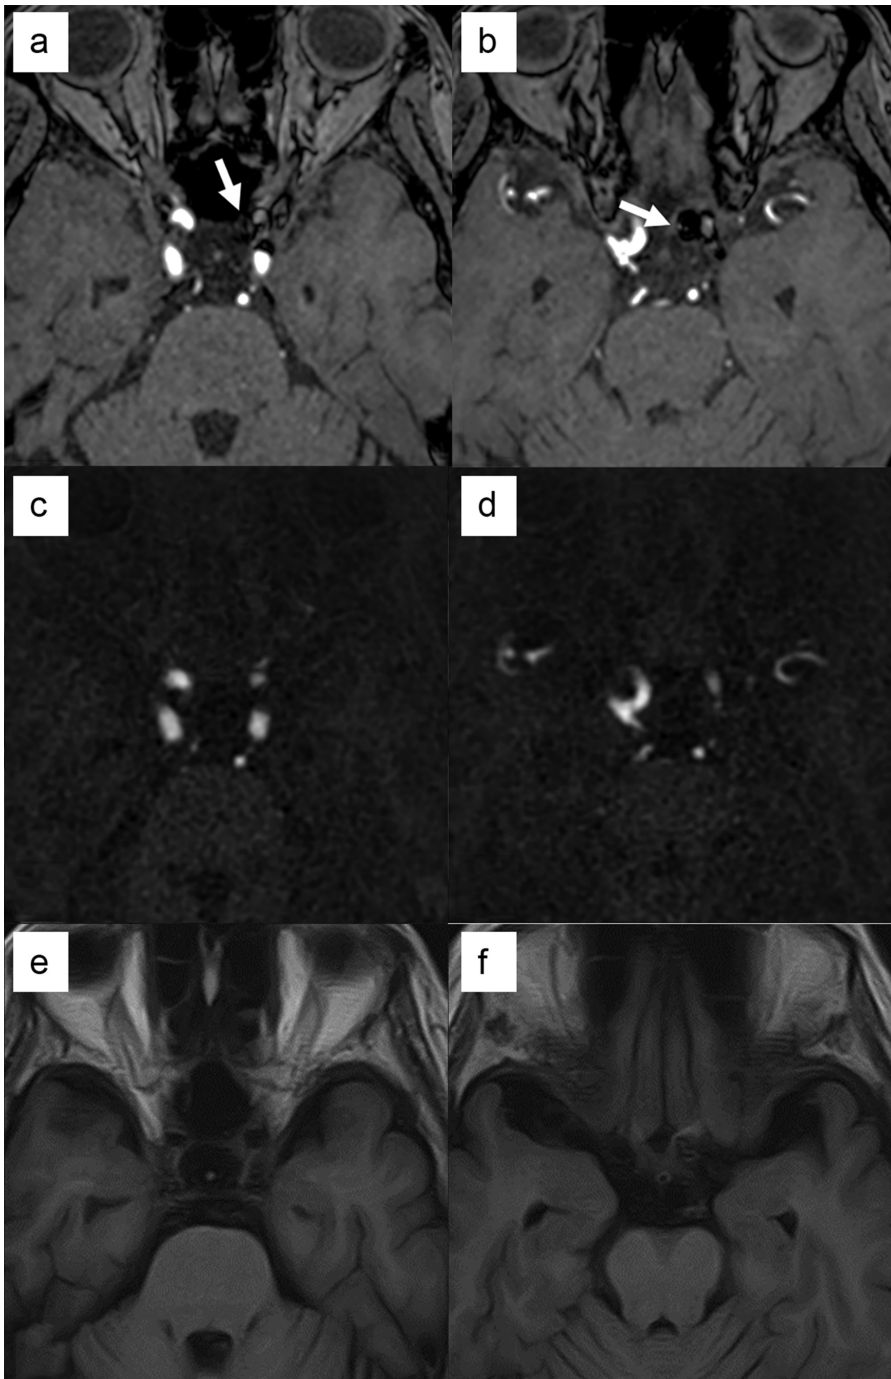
MRA findings in case 3. (a and b), TOF MRA. (c and d), Sub-UTE MRA. (e and f), T1-weighted imaging. TOF MRA revealed the punctate high signal intensities in both aneurysmal neck and dome (arrows in a and b, respectively). Since no obvious high signal intensity was detected on T1-weighted imaging at the sites corresponding to TOF MRA (e and f), both readers interpreted as residual aneurysm in TOF MRA. Sub-UTE MRA showed no flow signals in the aneurysmal dome and neck, and both readers, therefore, interpreted as complete occlusion. In the DSA, the diagnosis of complete occlusion was made. DSA, digital subtraction angiography; MRA, MR angiography; TOF, time-of-flight; UTE, ultra-short TE.
